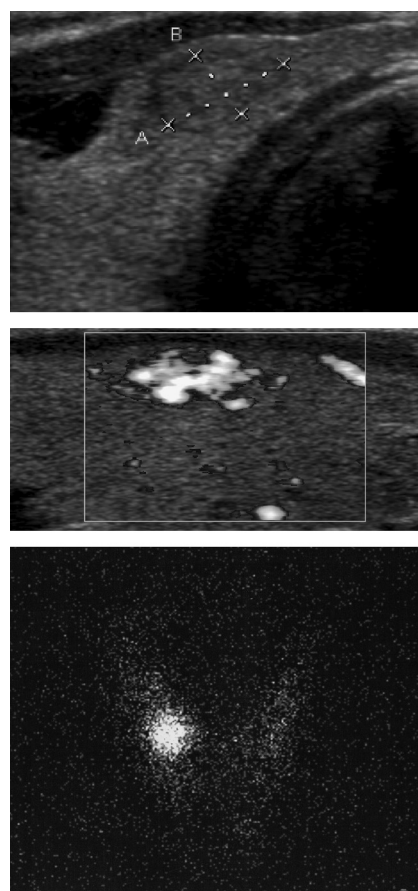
Top, Transversal sonography scan shows a 9 × 8 mm solid isoechoic right isthmolobar nodule. Middle, Longitudinal power Doppler sonography shows hypervascularization before HIFU treatment. Bottom, Hot right isthmolobar nodule with near-total suppression of extranodular iodine uptake is shown by the ¹²³I thyroid scan.
